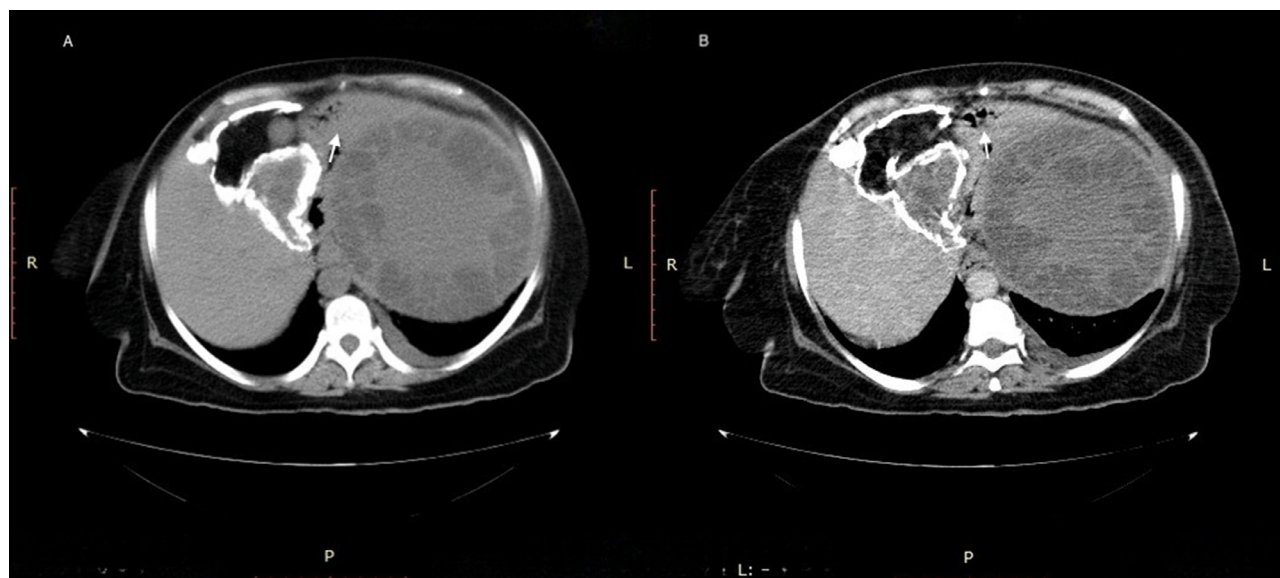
(A, B) Axial sections of the CT scan show a well-defined mixed attenuation and almost non-enhancing lesion involving almost all parts of the spleen. The lesion shows thin-walled, peripherally arranged daughter cysts with a central irregular soft-tissue component giving a spoke-wheel appearance, representing a type II hydatid cyst: cyst with daughter cysts and matrix. White arrows show disruption of the splenic capsule, which is in communication with a partly collapsed stomach.
